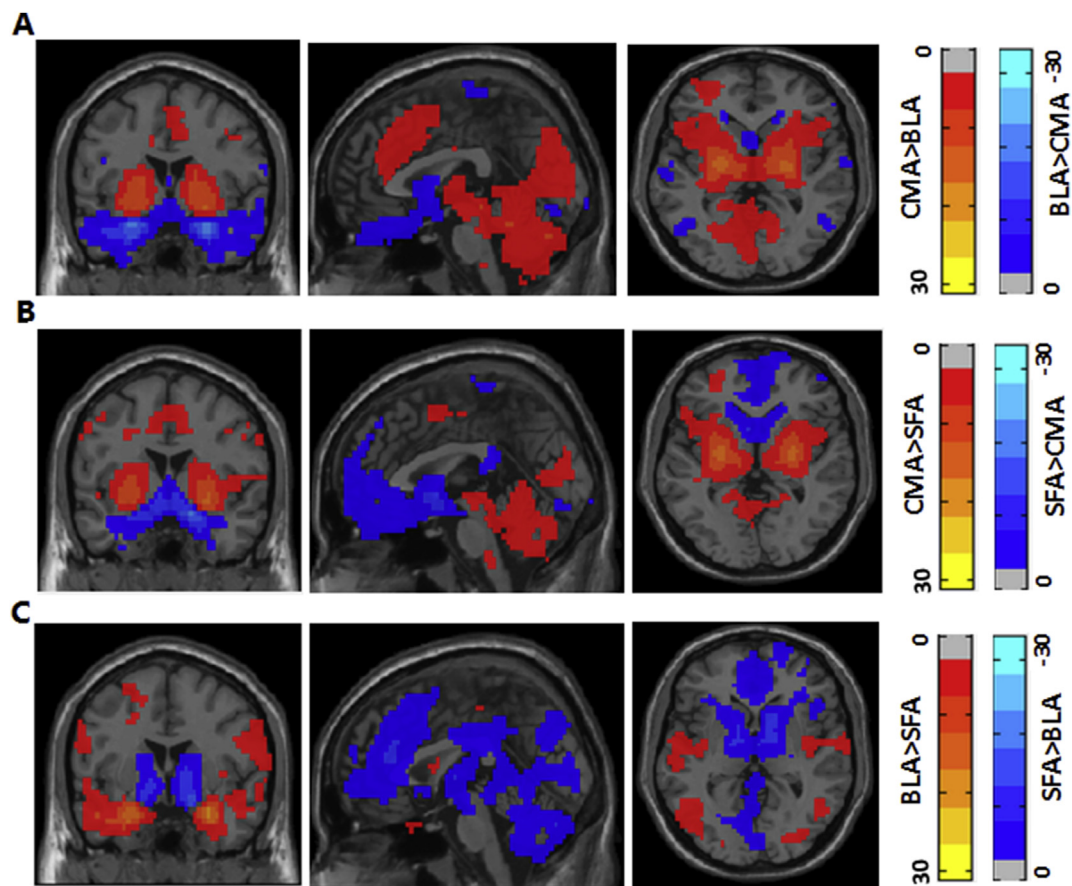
Brain areas showing differential connectivity to the centromedial (CMA), the basolateral amygdala (BLA) or superficial amygdala (SFA) during resting-state functional magnetic resonance imaging. (A) difference between CMA and BLA; (B) difference between CMA and SFA; (C) difference between BLA and SFA.
